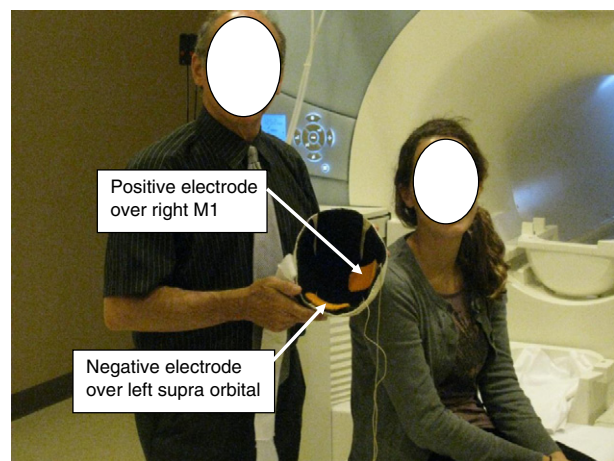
Setting up a subject for MRI scanning. The carbon-silicon electrodes were secured within the hermoplastic cup with velcro to assure appropriate positioning throughout the study.
